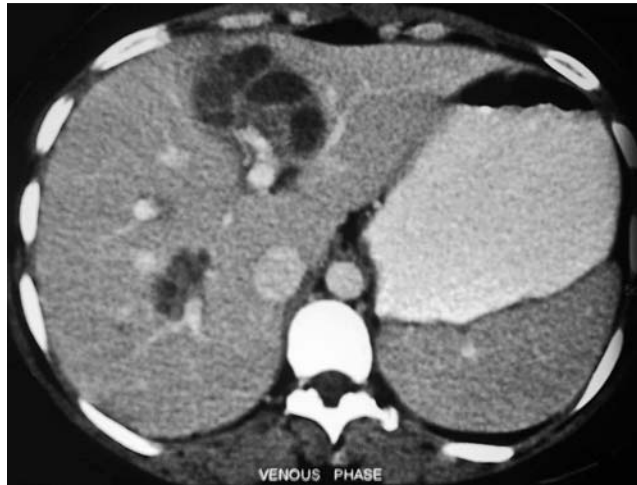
Portal venous phase computed tomography scan showing multiple hypodense non-enhancing complex cystic lesions in the liver.
